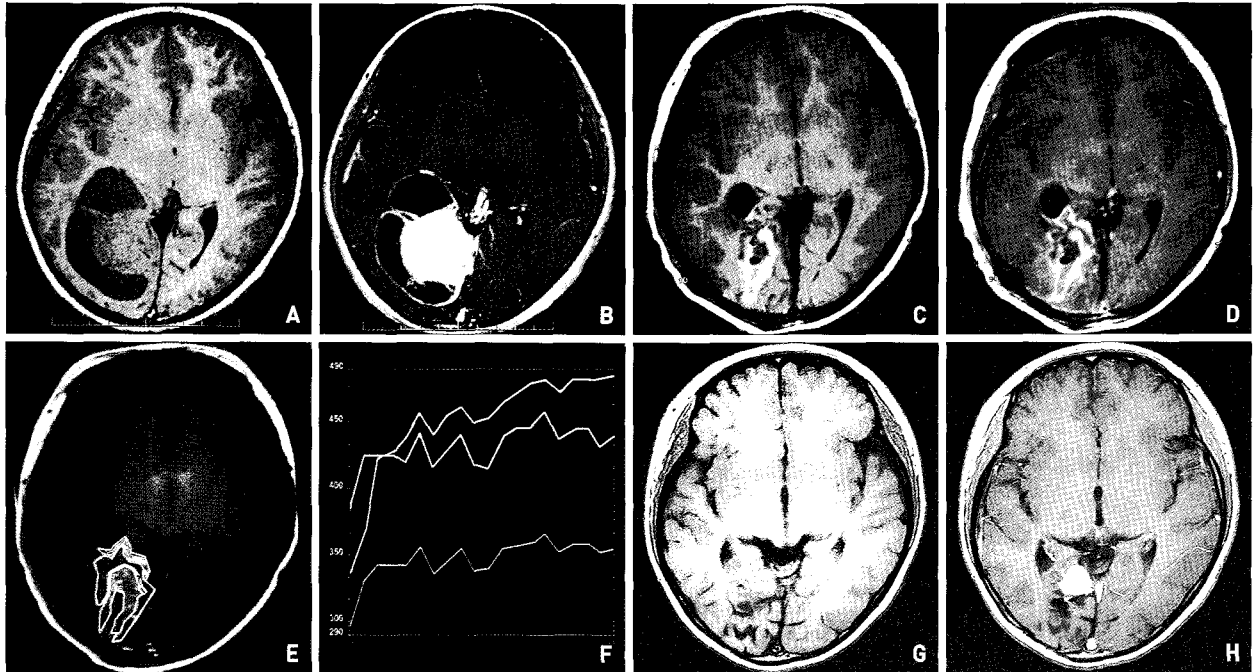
A 12-year-old female patient with ganglioglioma in the right occipital lobe (case 13). A : T1-weighted image shows iso-signal intensity with cyst formation. B : Enhancement is noted after administration of Gd-DTPA. C : T1-weighted image of magnetic resonance image on the first postoperative day. D : Marginal enhancement is noted after administration of Gd-DTPA. E : Region of interest for the enhancing (yellow) and surrounding (white and red) areas. F : "T pattern" is noted in all areas. G : T1-weighted image of the magnetic resonance image taken 4 years later. H : Strong homogenous enhancement is noted after administration of Gd-DTPA.
